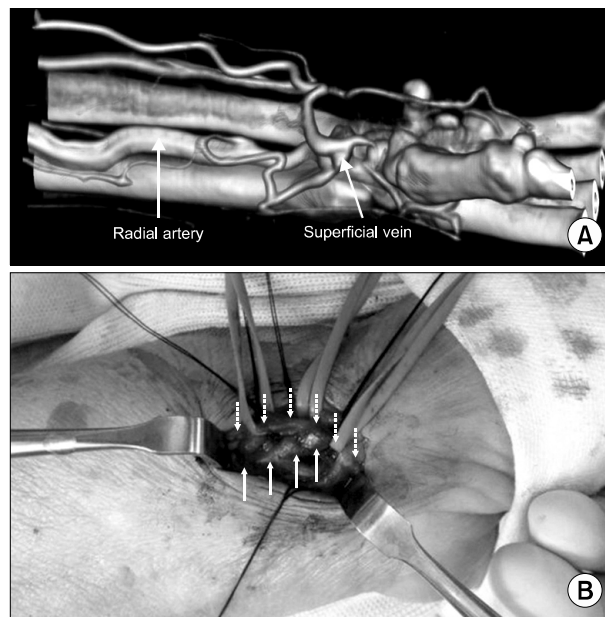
A vascular ultrasound scan for radial artery. It revealed connection between radial artery and superficial vein which suggested arteriovenous fistula.
